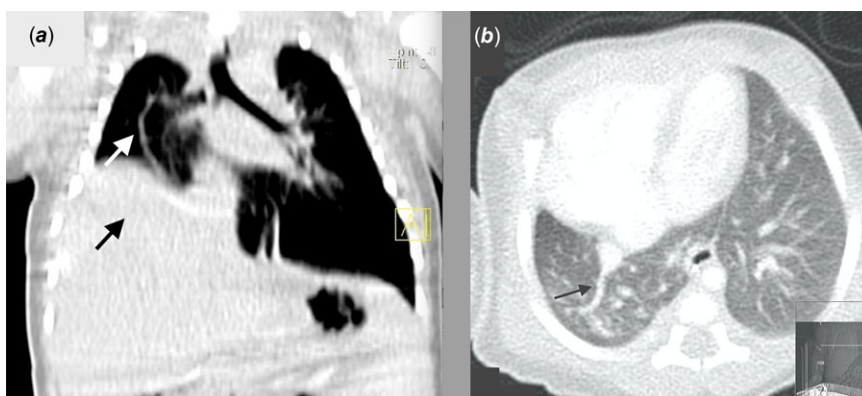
(a) Pre-surgical CT scan in coronal view showing an extensive homogenous hypodensity of the lower half of the right hemithorax (black arrow) and curved sword vascular sign - scimitar vein (white arrow). (b) Post-surgical CT angiography in transverse view revealing an abnormal pulmonary venous drainage into the right atrium (arrow).
